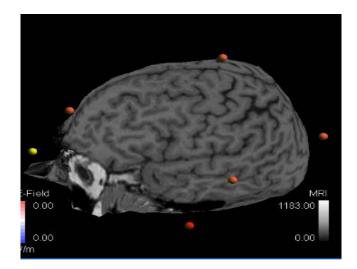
Participant #2 (C.S.) Reported findings of the current MRI noted two small areas of low signal intensity involving the subcortical white matter of the left occipital lobe and the left temporal lobe which were compatible with small areas of brain parenchymal loss.
